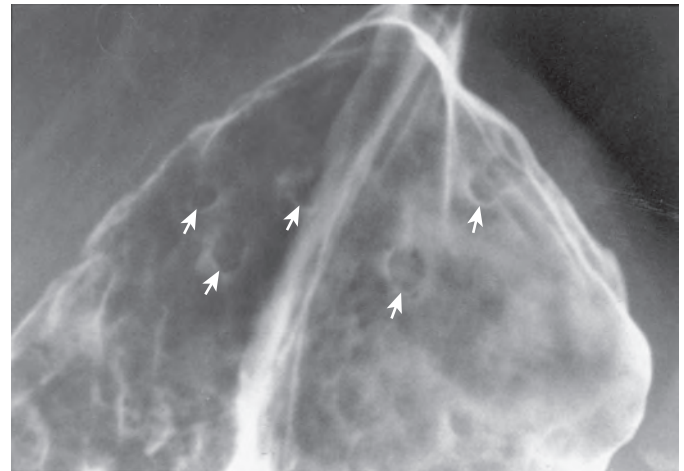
Fundic gland polyposis. Multiple tiny polyps (arrows) are present in the gastric fundus. These lesions have no malignant potential and are indistinguishable radiographically from hyperplastic polyps.
